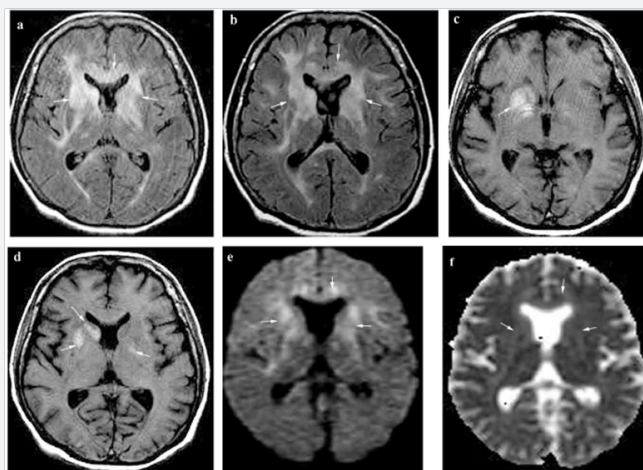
(a,b,c,d,e,f): MRI (October 19, 2012): Bilateral and asymmetric farce hyperintensities in Flair (a,b) w/ , diffusion (c) and ADC mop {d} involving the genu of corpus callosum, the white matter and the lenticulo-capsulo-caudate regions. Note T1 w hyperintense areas in the right lenticulo-caudate region and into the left globus pallidum (e,f).
